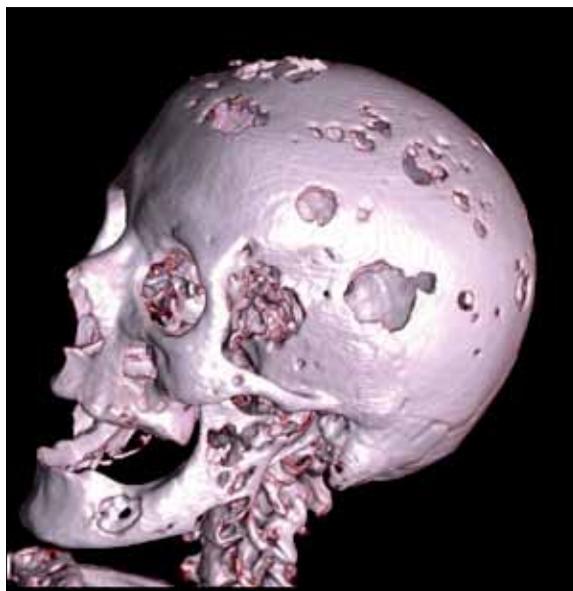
CT examination. 3D reconstruction. Disseminated focal lytic lesions in facial and calvarial bones
